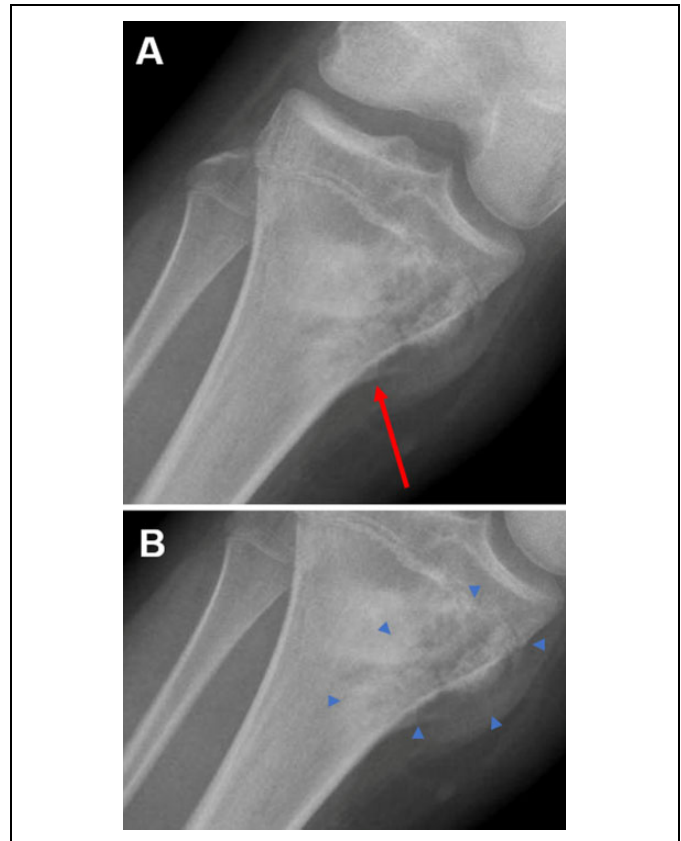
Simple radiograph of the right distal femur, proximal tibia, and proximal fibula. Note the large irregular mass obscuring the proximal tibial metaphysis. Red arrow denotes Codman triangle (A). Blue arrowheads delineate extension of tumor into the surrounding soft tissue (B). The mass is approximately 9 cm at its greatest dimension, according to imaging measurement of a subsequent computed tomography (CT) scan.
